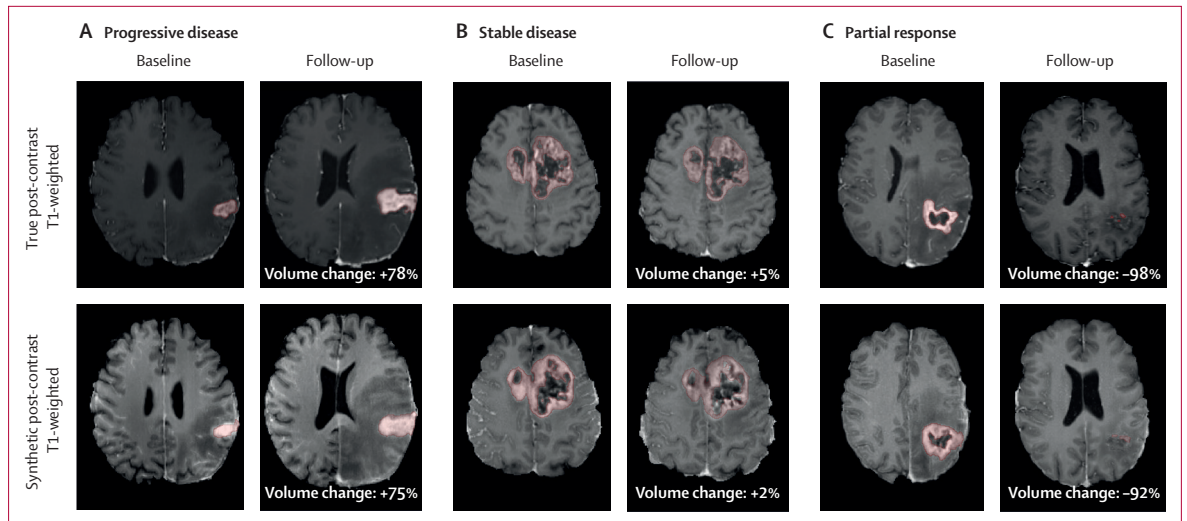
True and synthetic post-contrast T1-weighted sequences
